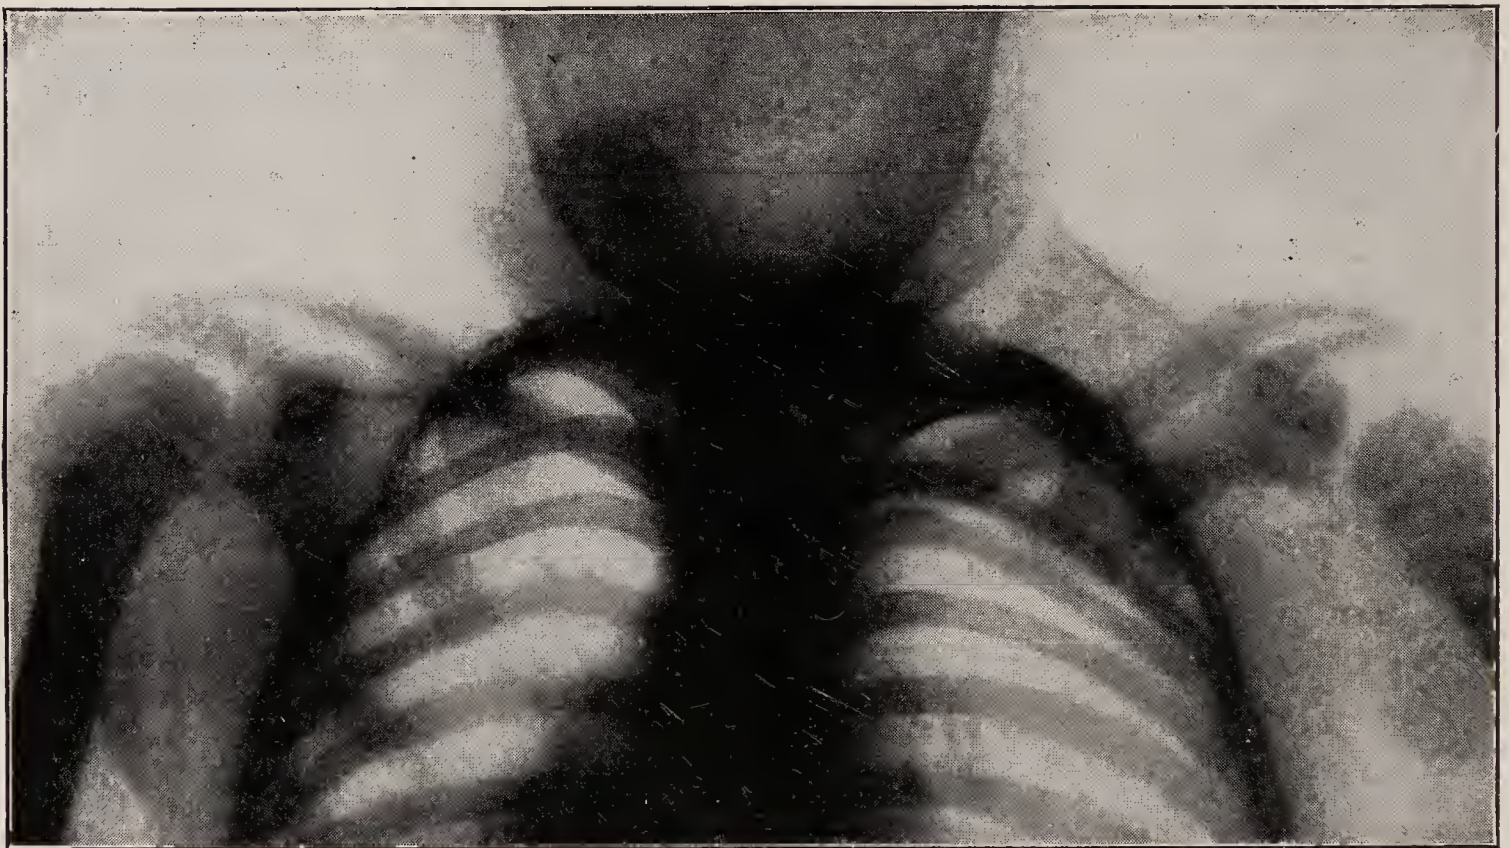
X-ray of Sprengel's deformity.
